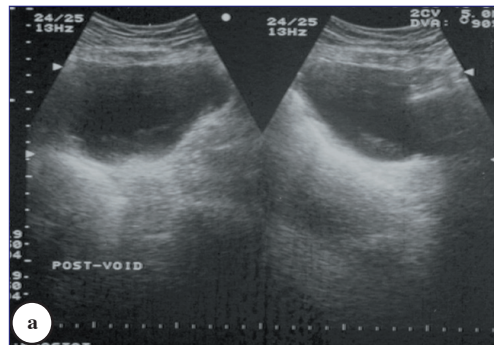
a) Post voiding ultrasound examination of the pelvis showing distended urinary bladder. b) Brain SPECT showing perfusion defect in the left parietal lobe (arrows).
